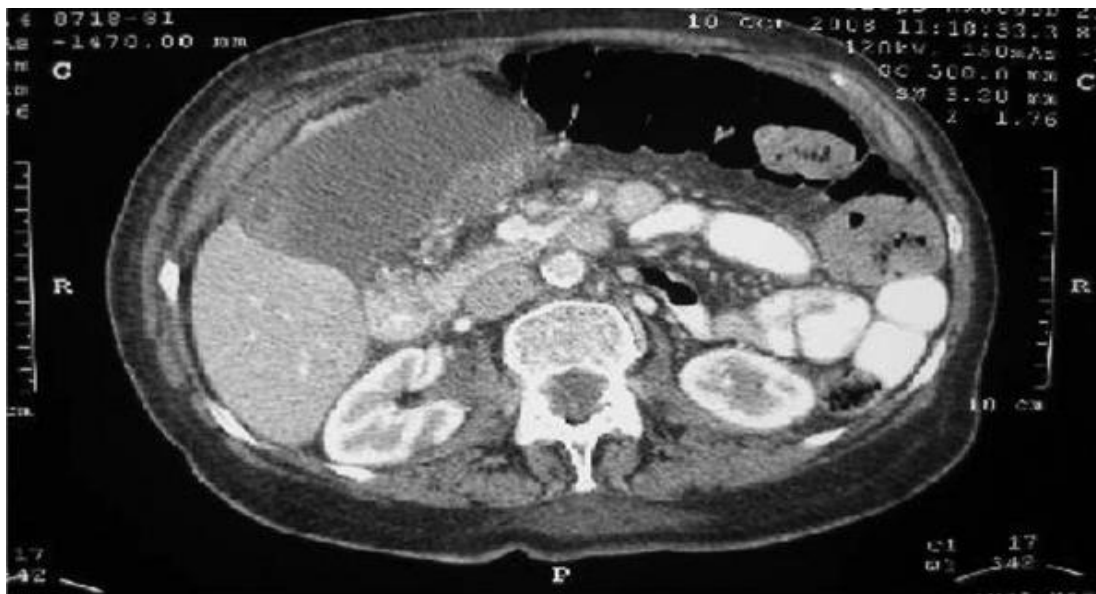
Abdominal computed tomographic scan showing an enlarged gallbladder with asymmetric thickening of the wall with a low-density filling. ⁽⁷⁾
